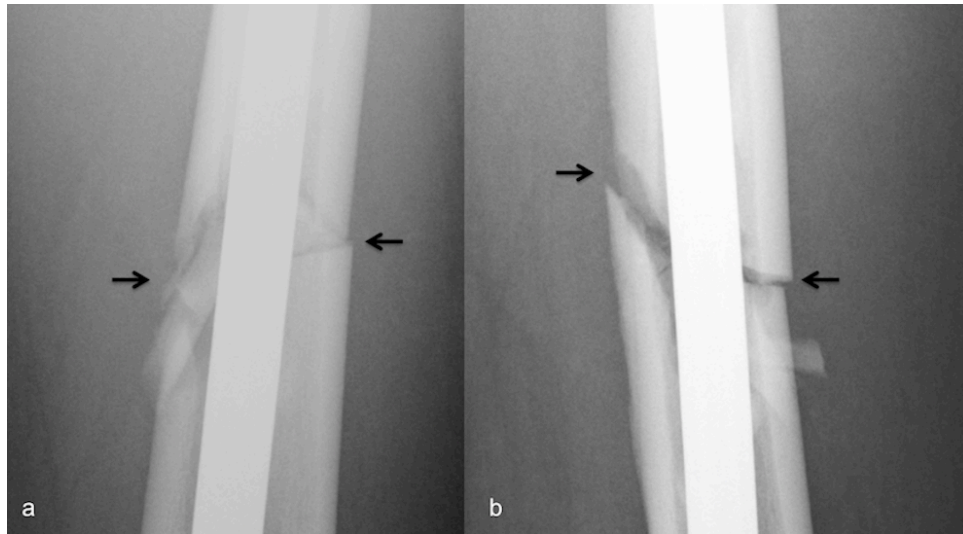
(a) AP and (b) lateral radiographs of a nailed femur. The score of each cortical area (arrows) was 2 because of the visibility of cortical discontinuity and the presence of non-bridging callus. RUS value was 8.
